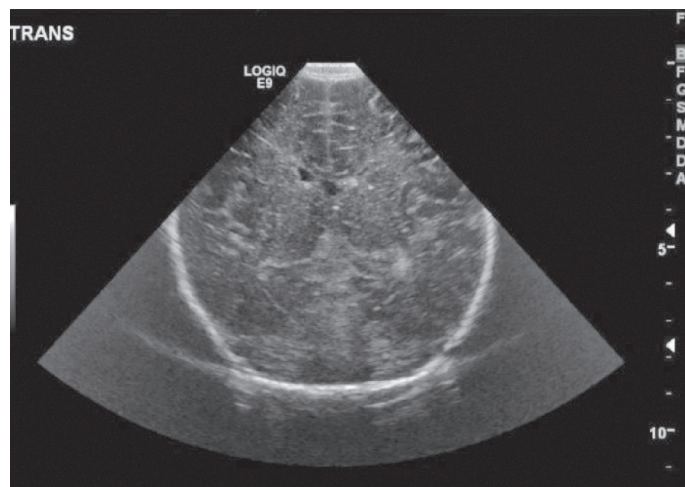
Head ultrasound showing normal posterior fossa ruling out Dandy Walker Malformation
